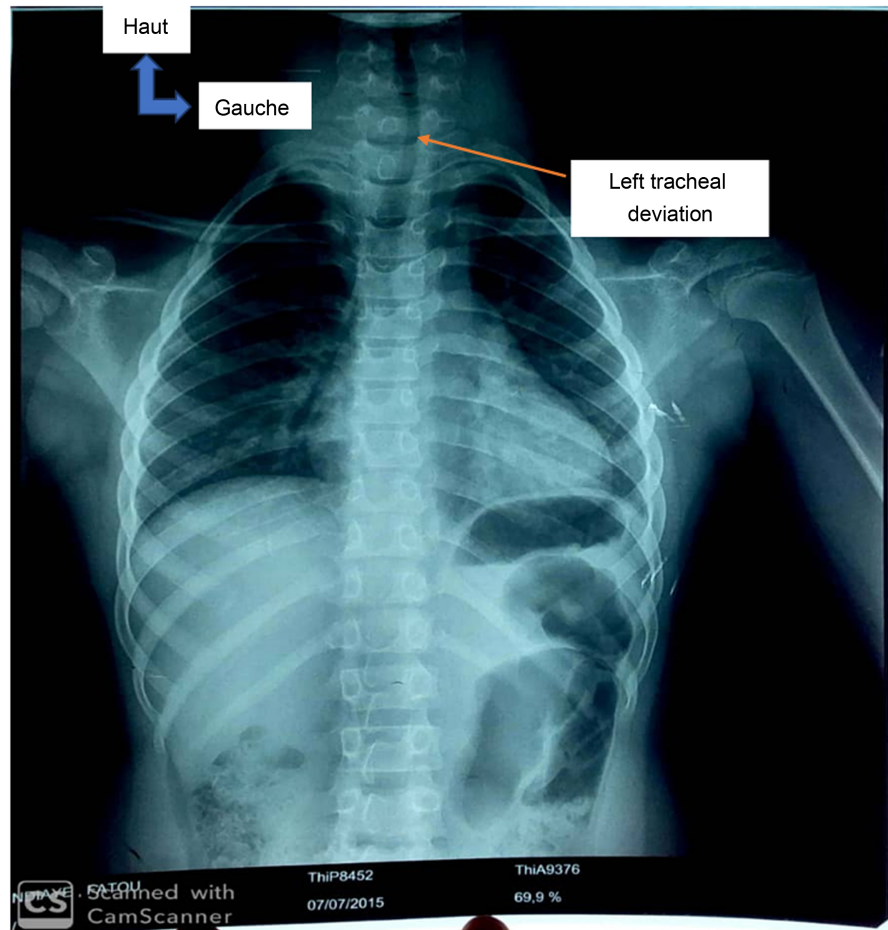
Frontal chest X-ray taking the neck showing a deviation of the trachea to the left in a 15-year-old patient due to a voluminous compressive goiter.
